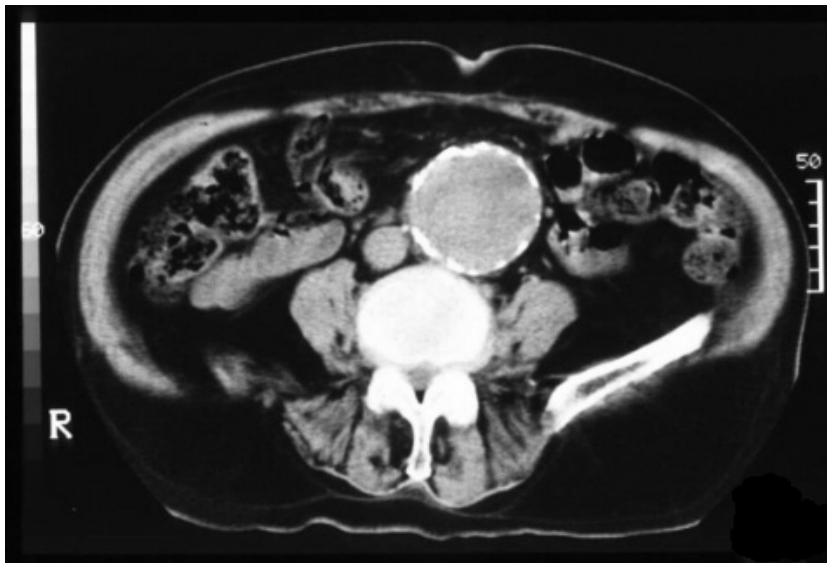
CT scan showing infrarenal abdominal aortic aneurysm
